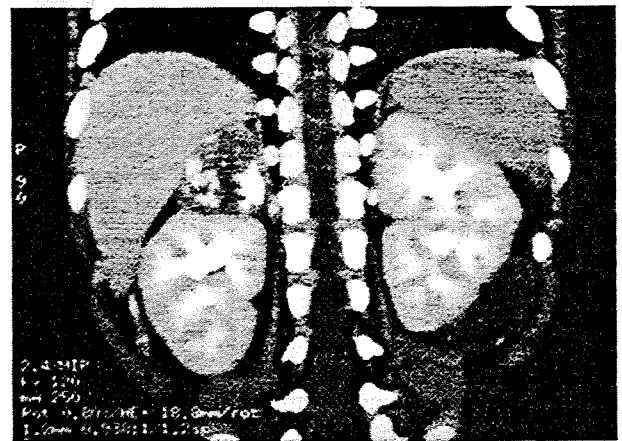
Prechemotherapy CT scan image in axial section showing calcification in a case of neuroblastoma
